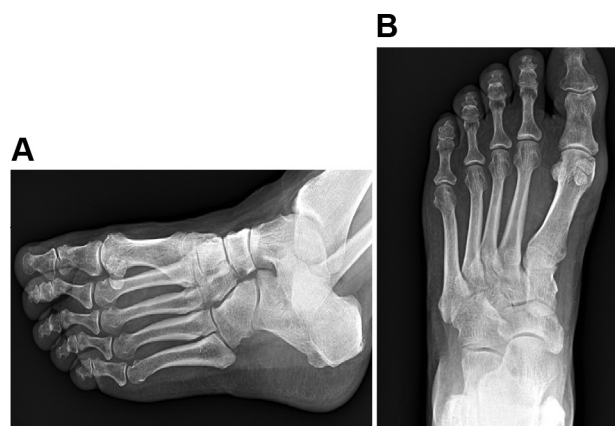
Lateral oblique (A) and anteroposterior (B) radiographs without specific findings of cubonavicular coalition.
